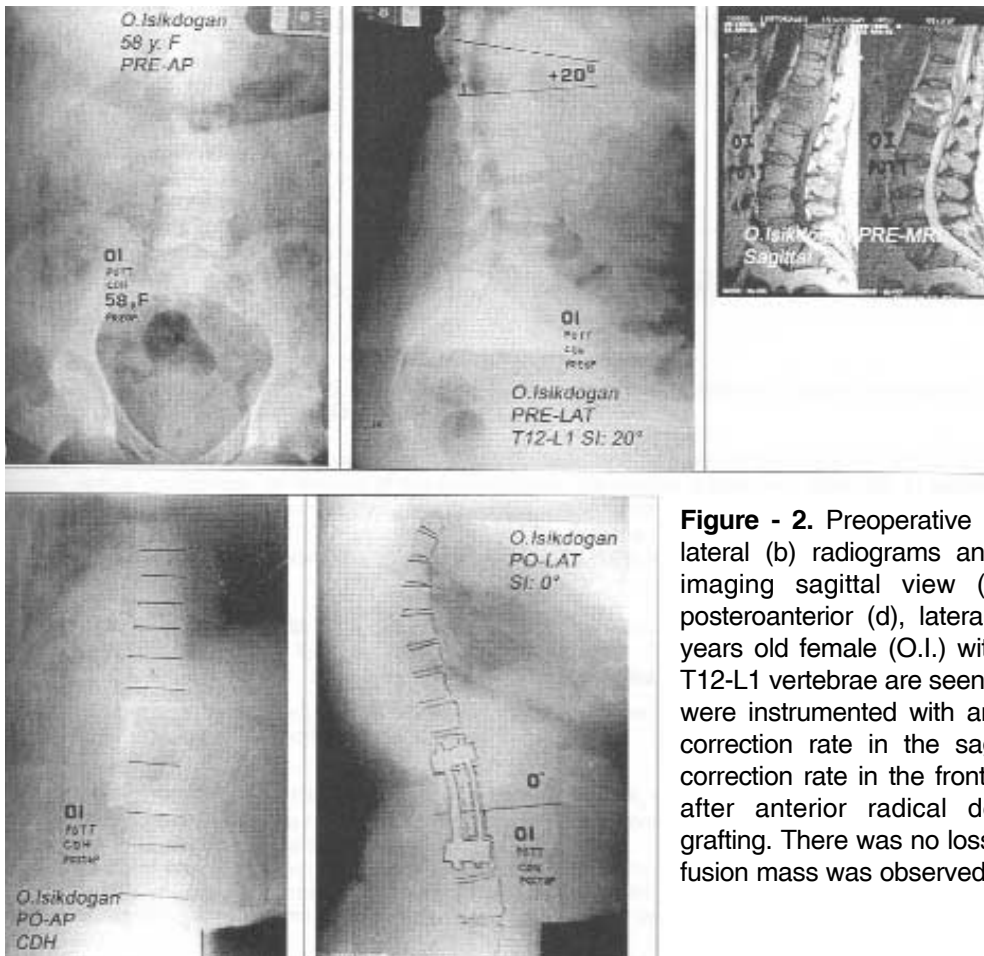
Preoperative posteroanterior (a) and lateral (b) radiograms and magnetic resonance imaging sagittal view (c) and postoperative posteroanterior (d), lateral (e) radiograms of 58 years old female (O.I.) with Pott's disease in the T12-L1 vertebrae are seen. Three mobile segment were instrumented with anterior CDH and 100% correction rate in the sagittal plane and 100% correction rate in the frontal plane were obtained after anterior radical debridement and strut grafting. There was no loss of correction and solid fusion mass was observed in the last visit.
